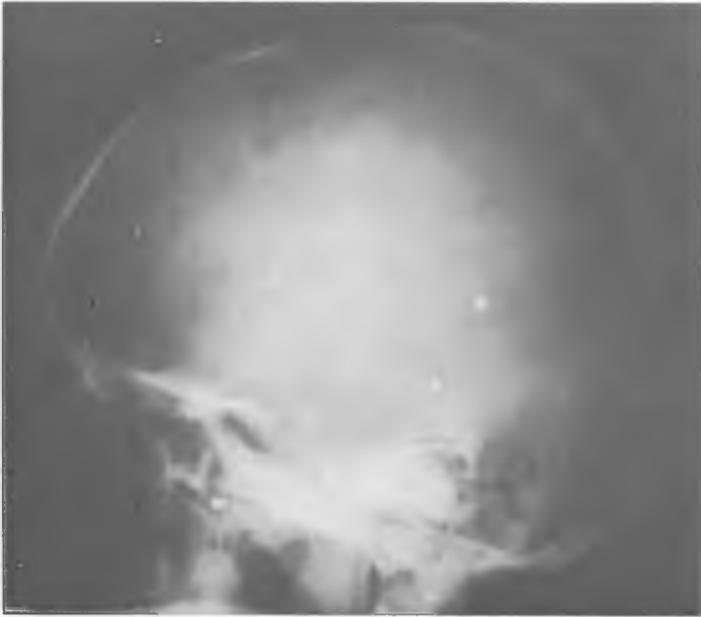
Small metallic foreign bodies on the skull X-ray (lateral view) are diagnosed
